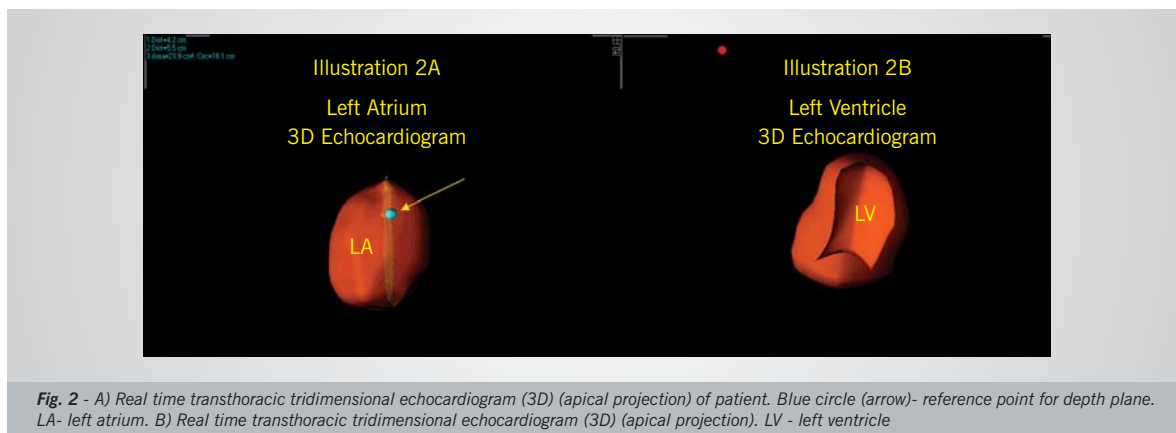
A) Real time transthoracic tridimensional echocardiogram (3D) (apical projection) of patient. Blue circle (arrow)- reference point for depth plane. LA- left atrium. B) Real time transthoracic tridimensional echocardiogram (3D) (apical projection). LV - left ventricle
